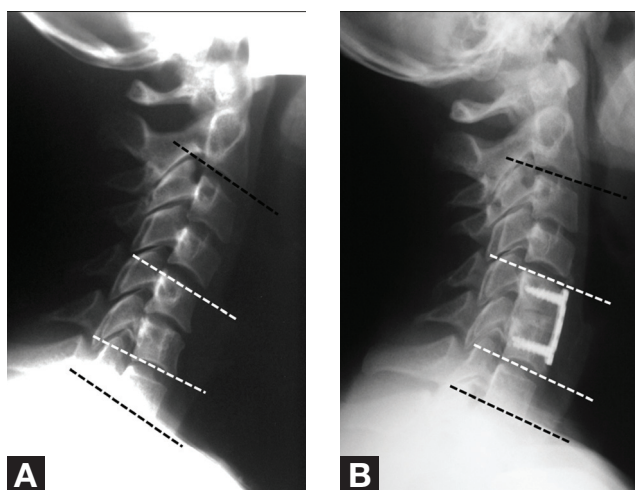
(A) Preoperative cervical lateral radiograph with C2-C7 measuring 2° of kyphosis (black line) and C5-C6 measuring 5° of kyphosis (white line). (B) Postoperative cervical lateral radiograph with C2-C7 measuring 6° of lordosis (black line) and C5-C6 measuring 3° of lordosis (white line). This translates to an 8° increase in total cervical lordosis and segmental lordosis.
